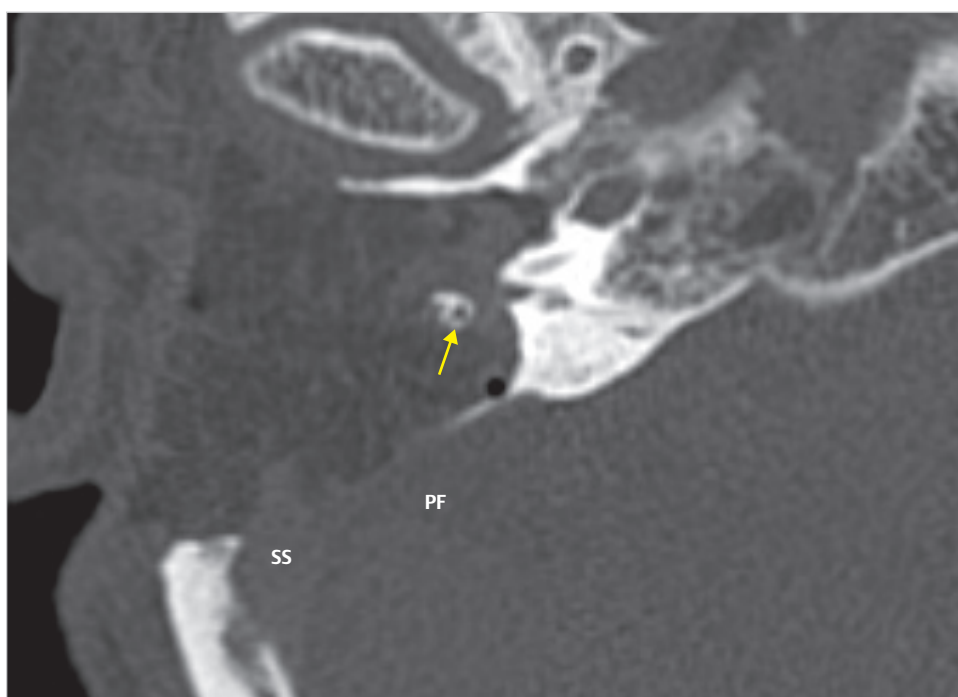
The postoperative CT shows sufficient removal of bone from the temporal bone. The arrow indicates the fallopian canal. PF, posterior fossa; SS, sigmoid sinus.
